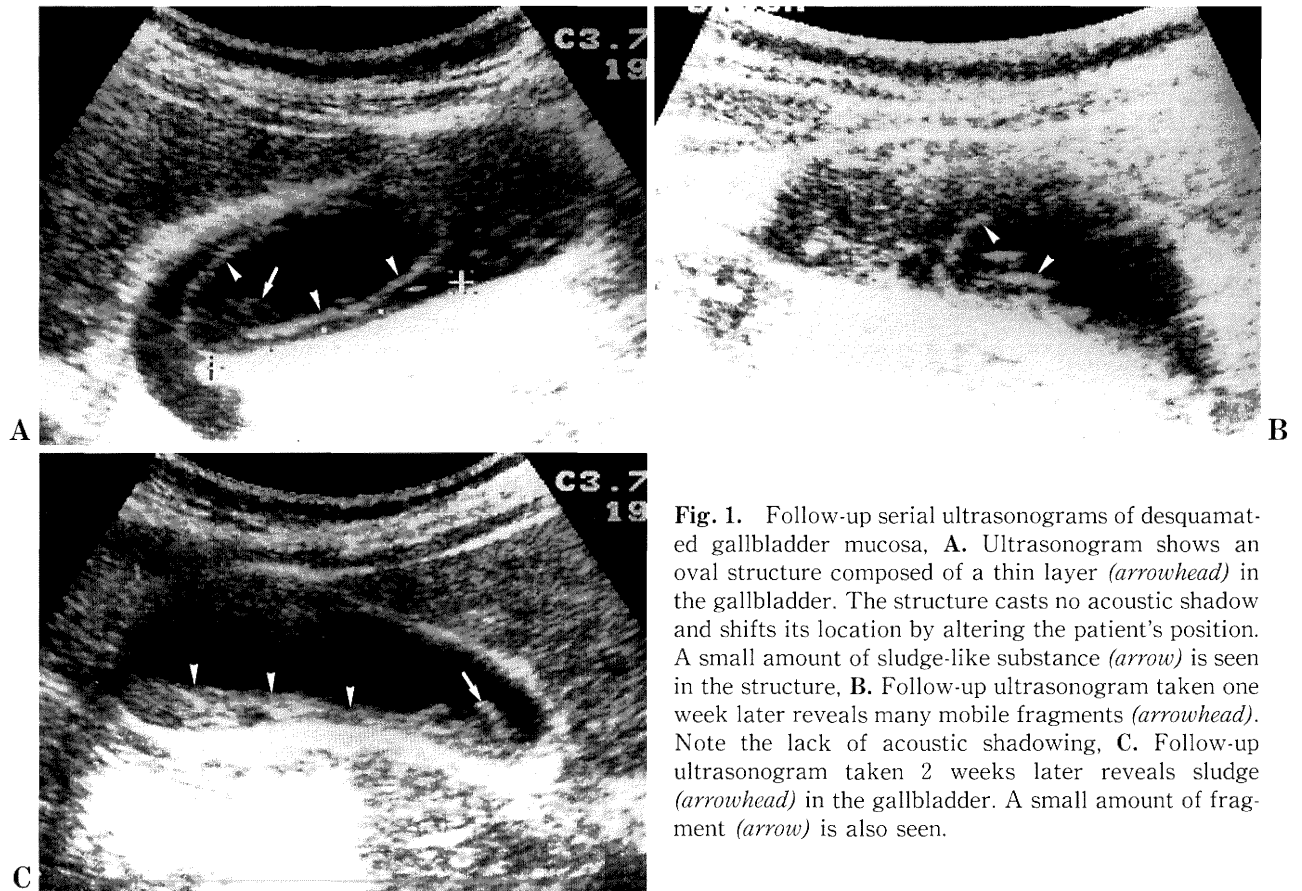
Follow-up serial ultrasonograms of desquamated gallbladder mucosa, A. Ultrasonogram shows an oval structure composed of a thin layer (*arrowhead*) in the gallbladder. The structure casts no acoustic shadow and shifts its location by altering the patient's position. A small amount of sludge-like substance (*arrow*) is seen in the structure, B. Follow-up ultrasonogram taken one week later reveals many mobile fragments (*arrowhead*). Note the lack of acoustic shadowing, C. Follow-up ultrasonogram taken 2 weeks later reveals sludge (*arrowhead*) in the gallbladder. A small amount of fragment (*arrow*) is also seen.
